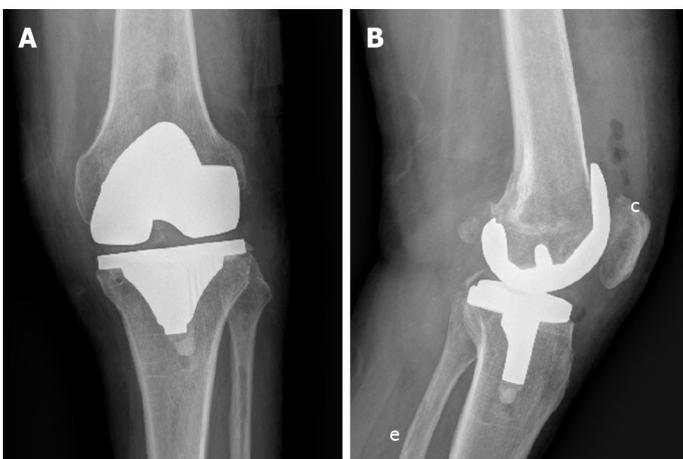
Postoperative front and lateral X-ray images of the left knee. A: Front X-ray image of the left knee; B: Lateral X-ray image of the left knee.
